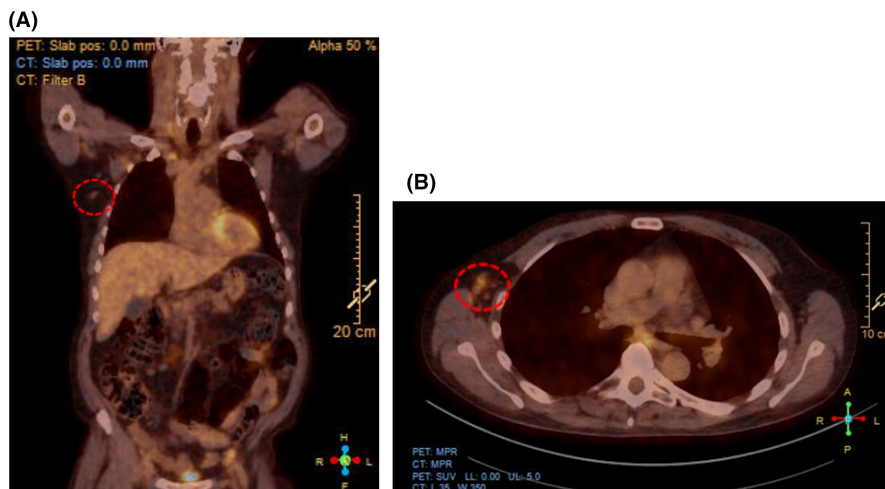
PET-CT after BV-CHP treatment and subsequent BEAM-conditioned autologous stem cell transplantation of the (A) thoracic region and the (B) iliac region. BEAM, carmustine, etoposide, cytarabine, and melphalan; BV-CHP, brentuximab vedotin plus cyclophosphamide, doxorubicin, and prednisone; PET-CT, positron emission tomography-computed tomography.
